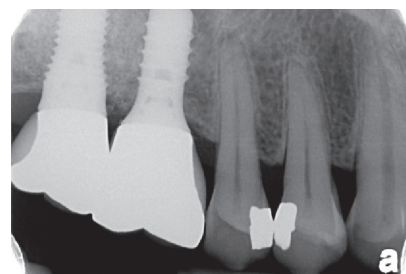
Periapical radiograph taken before removing the tooth fragment showed moderate bone resorption and apical radiolucency at 15.
